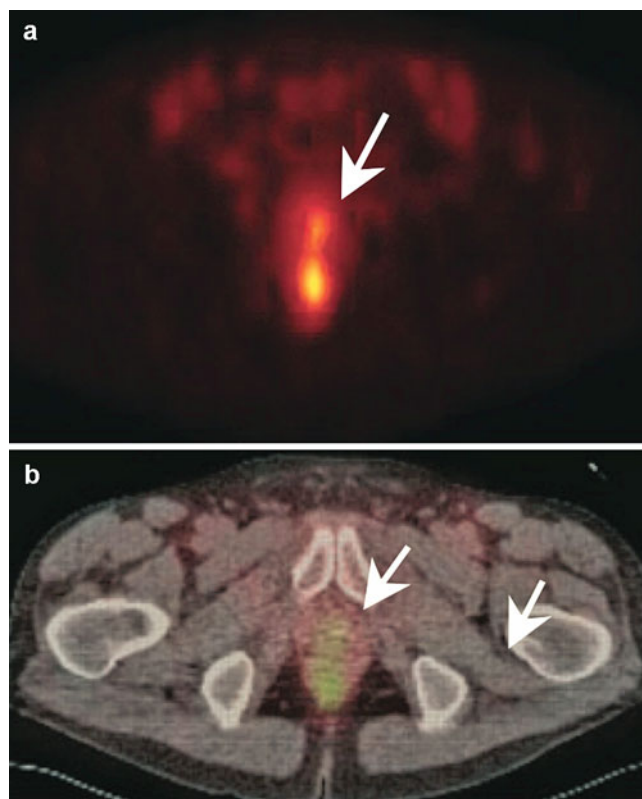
Example of the use of ^{11}C -acetate PET to detect recurrence. Focal hyperactivity is seen in the prostate bed (a) and the fused imaging with the corresponding CT (b). The small, focal hyperactivity (arrow) reached a SUV of 2.5 (Used with permission from publisher. Veas et al. [77])
